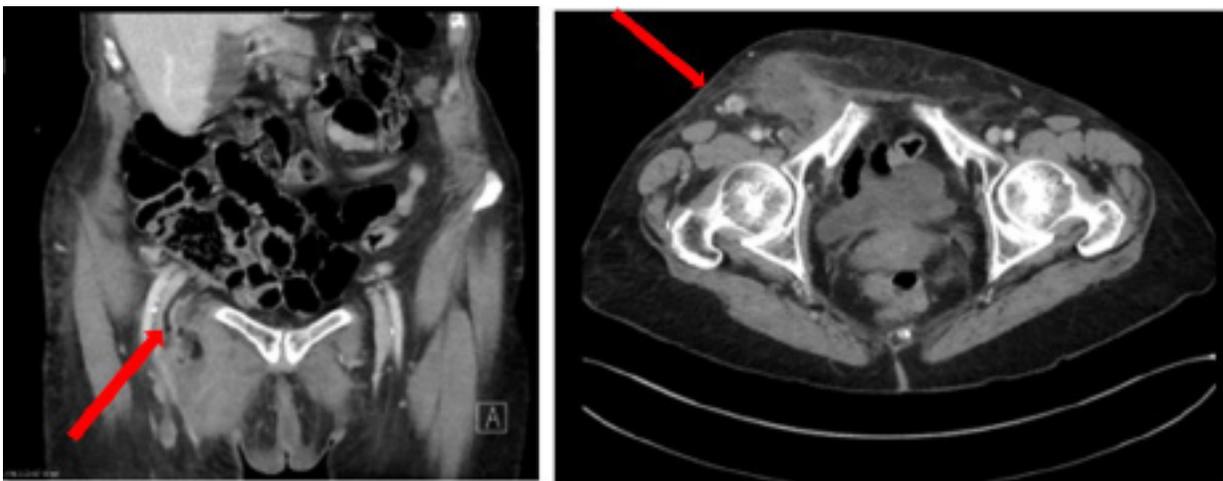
Abdominal CT scanner exposing the appendix in the hernia sac (red arrows).
